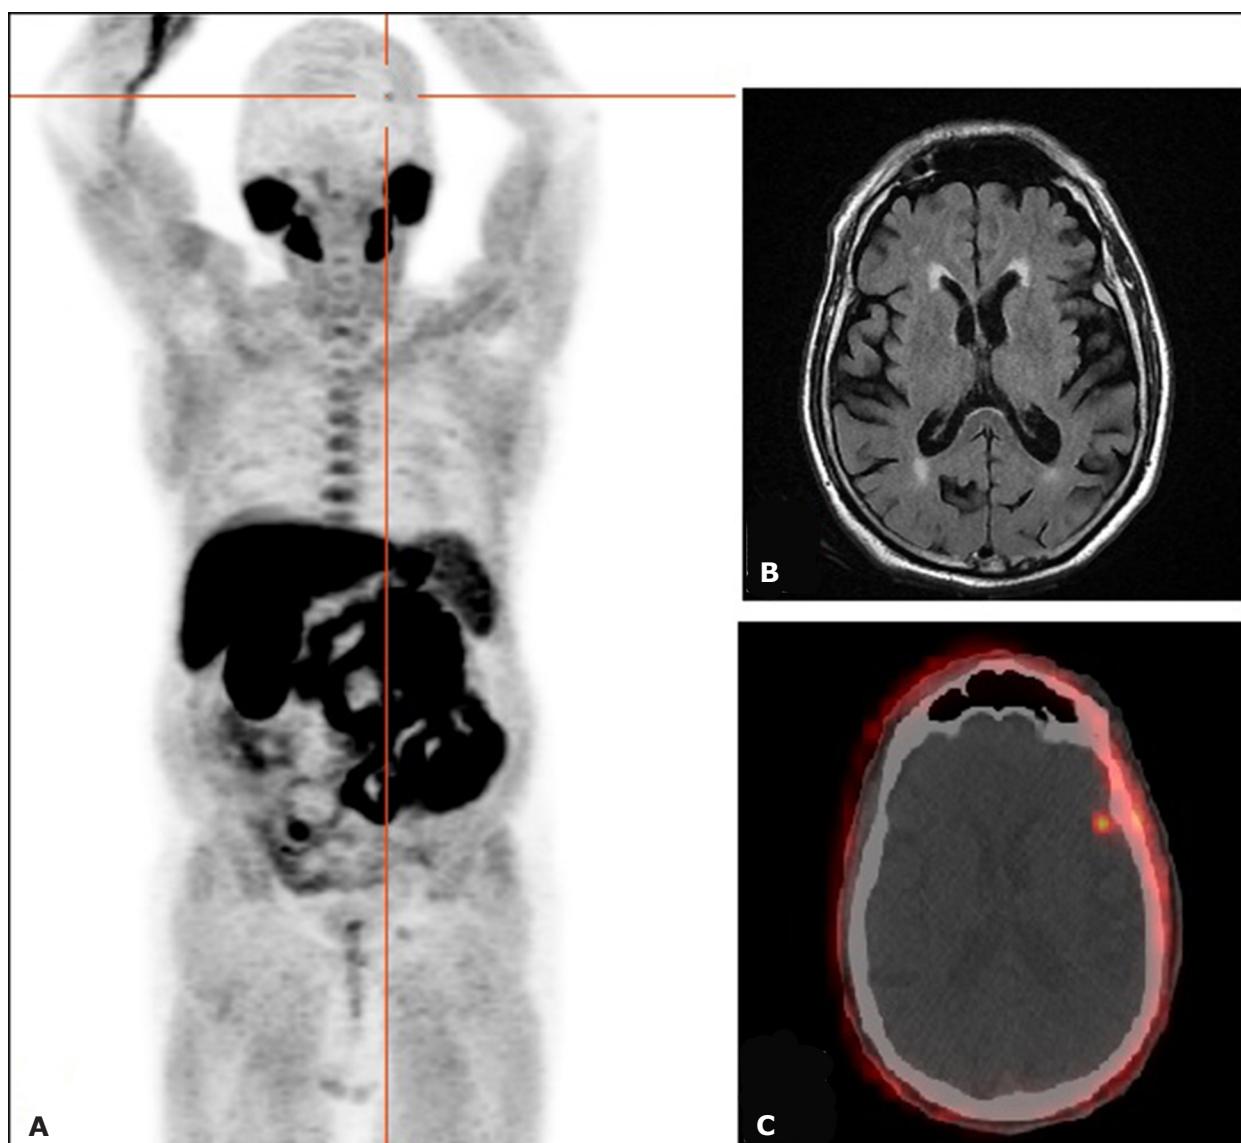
A: ^{18}F -fluorocholine PET/CT MIP; B: axial Brain MRI T2 Flair; C: ^{18}F -fluorocholine PET/CT axial fusion image of the brain: an isolated uptake focus is noted in the left temporal lobe. Brain MRI confirmed the meningioma diagnosis
